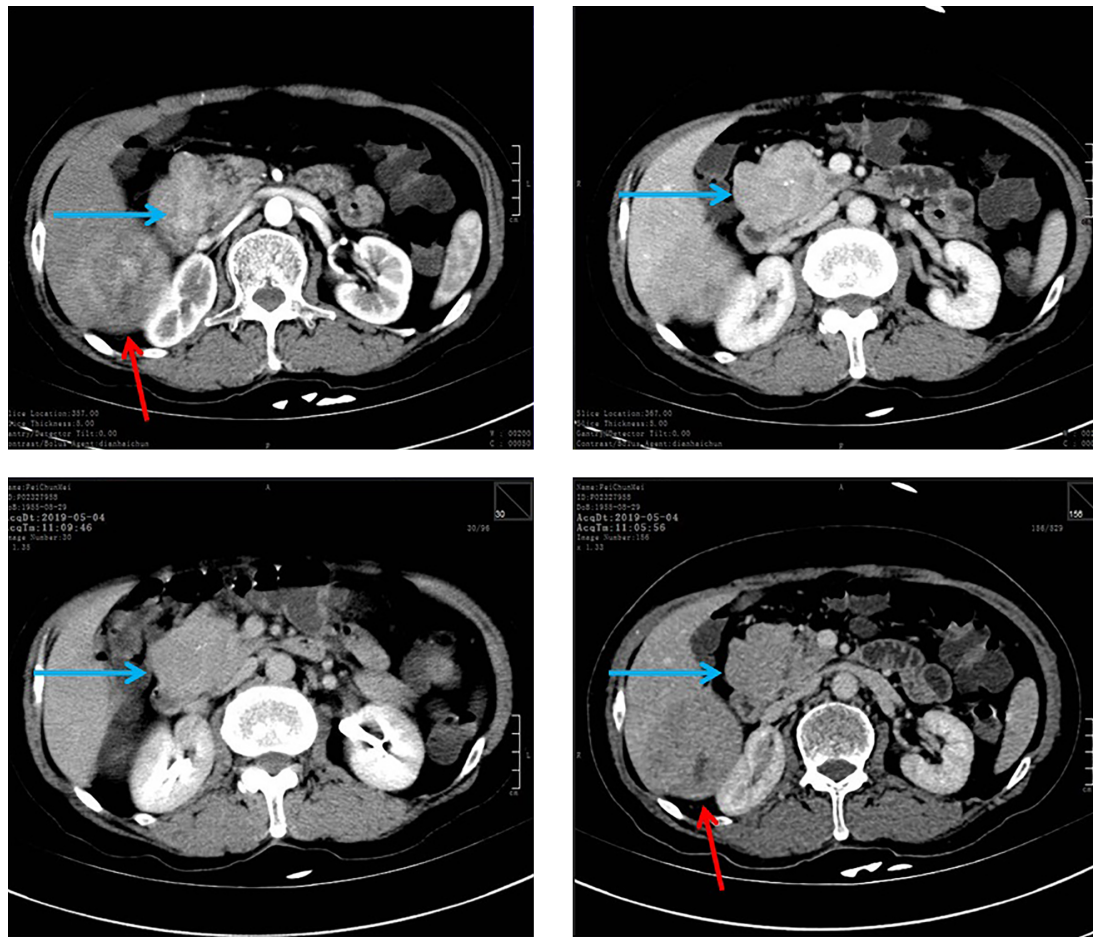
Abdominal computed tomography (CT) images. A, non-contrast CT image; B, dynamic contrast-enhanced CT images; B, arterial phase image; C, portal phase image; D, delayed phase images. Blue arrow: pancreatic lesion; red arrow: hepatic lesion.
